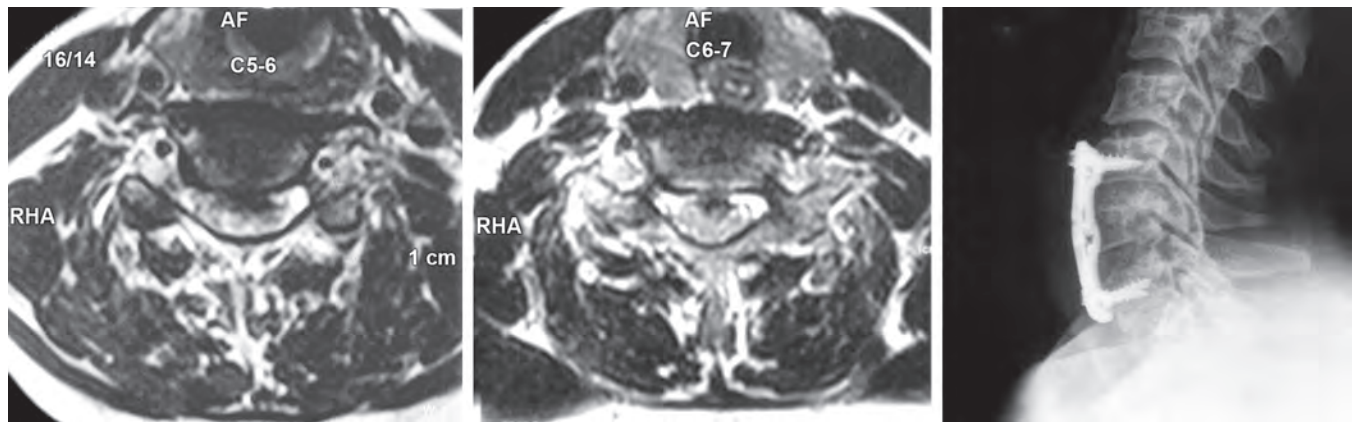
MRI cervical spine axial view showing C5-6 and C6-7 disc prolapse of patient who presented with cervical myelopathy. She underwent ACDFI. X-ray cervical spine showing fusion after 5 months
